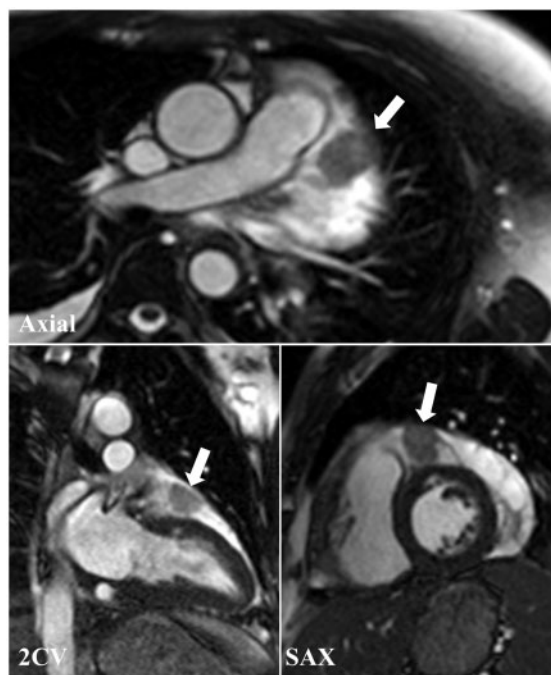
Steady state free-precession cine cardiac magnetic resonance imaging confirming suspicious mass. See also [Supplementary material online, Files S1–S3](#). SAX, short axis; 2CV, 2-chamber view.
